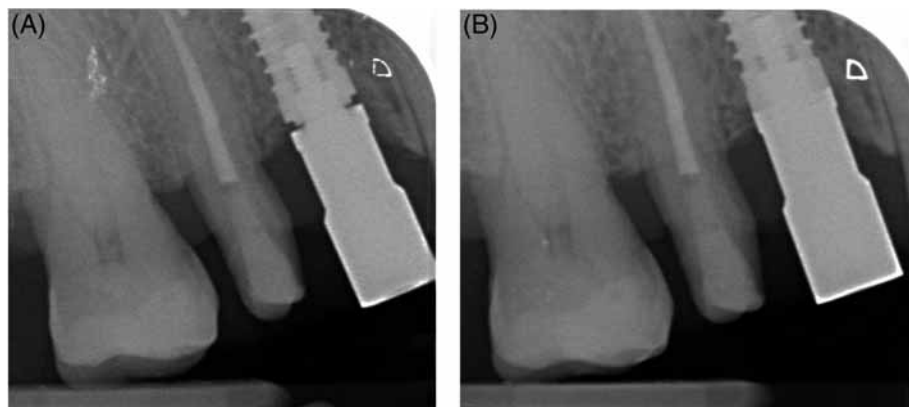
Radiographic examination should reveal improper vertical seating of the ISBs every time the interface is not visually inspectable. Only metal components allow the identification of the incorrect (A) or correct (B) adaptation to the implant platform. PEEK is a radiolucent material
